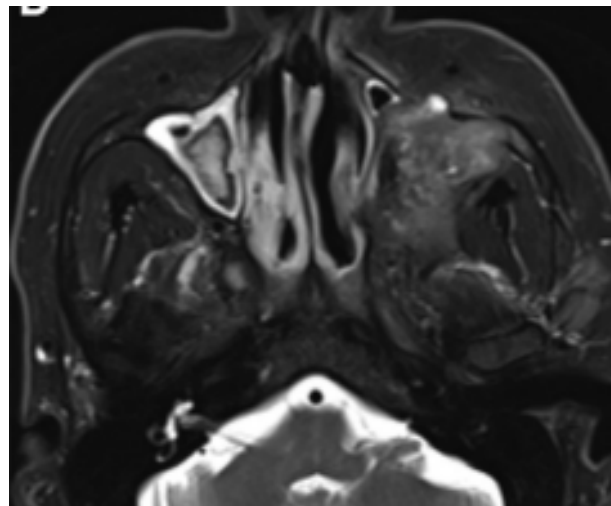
Chronic invasive fungal rhinosinusitis. MRI scan, T2 mode with suppression of adipose tissue. An axial section shows a lesion with a low signal on the left.
